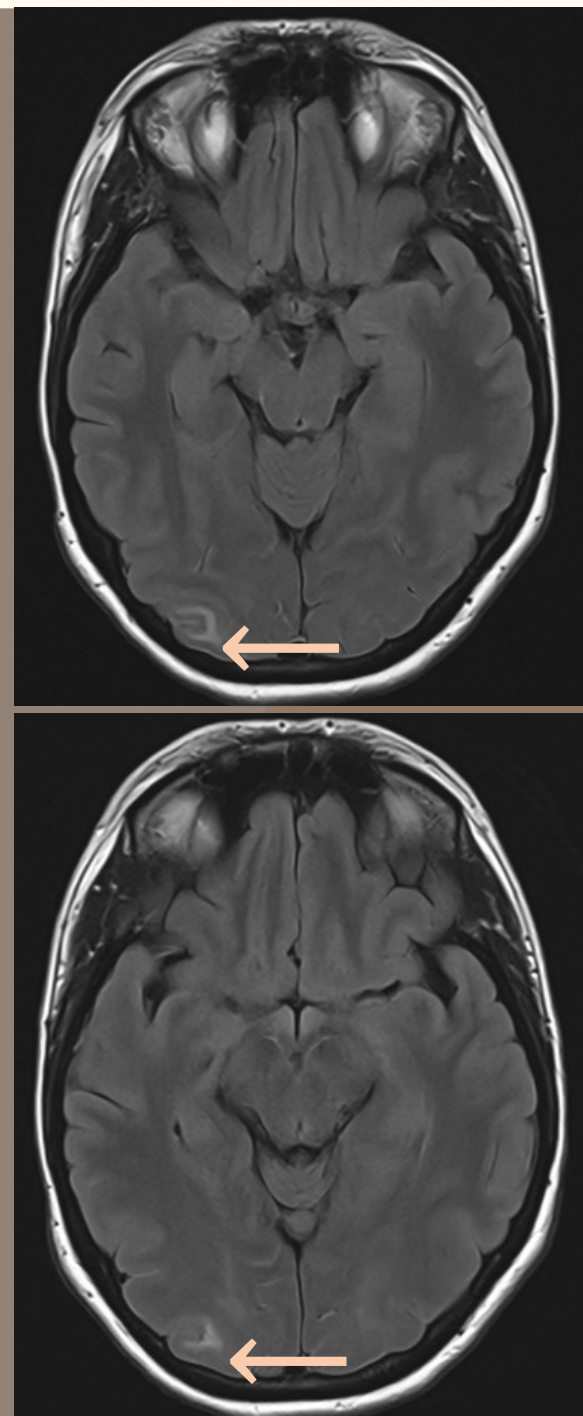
occipital lobe vasogenic oedema (→) on MRI images
